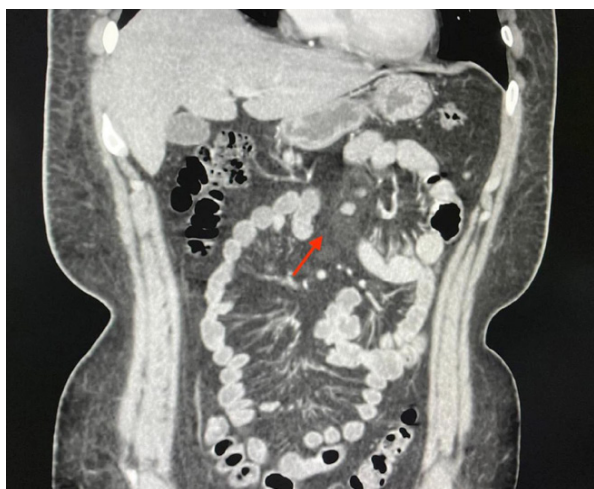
CT abdomen/pelvis with contrast showed a focal area of mesenteric panniculitis seen at the left upper abdomen (red arrow).
